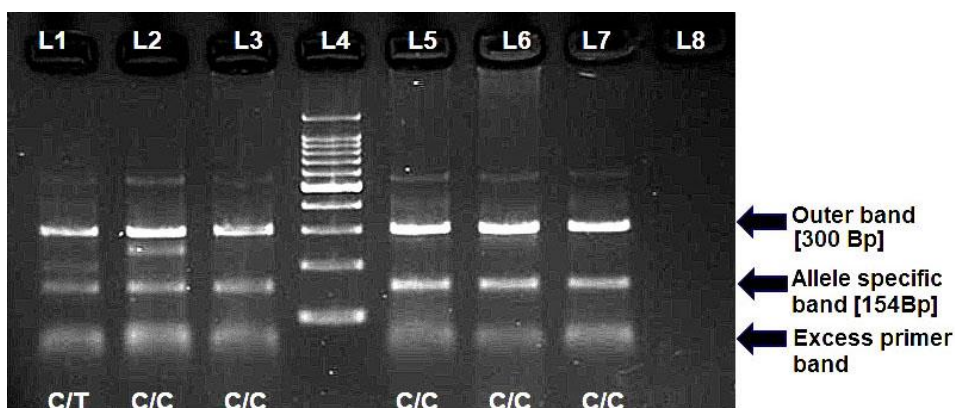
Agarose (1.6) gel electrophoresis results of ARMS-PCR. Lanes: L1-CT genotype, L2 & L3-CC genotype, L4-100 Bp DNA Ladder, L5, L6 & L7 CC genotype, L8-Negative control.
